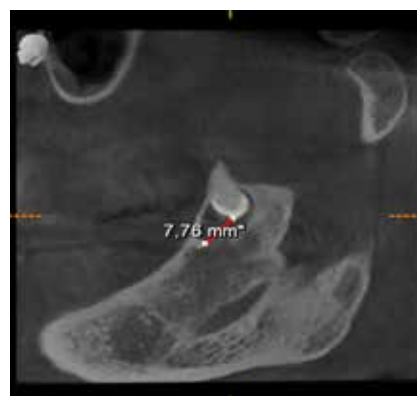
CBCT lateral view of the left coronoid process
